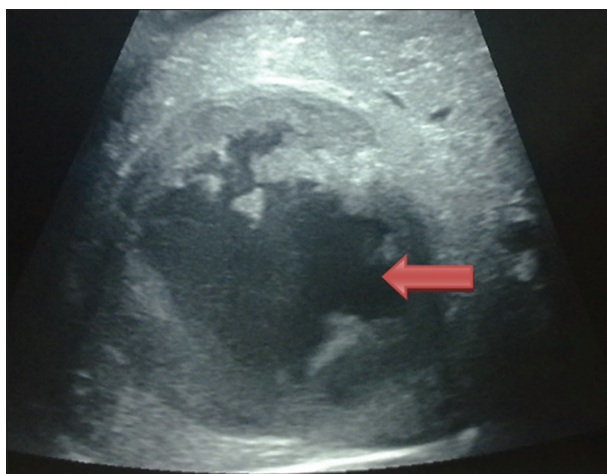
Ultrasonography showing heterogeneously hypoechoic lesion suggestive of abscess.
